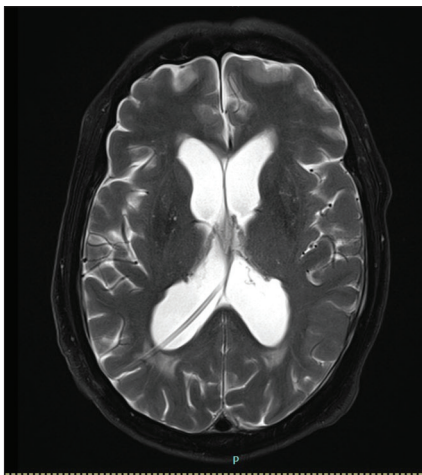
MRI brain: Pan ventriculomegaly with patent shunt *in situ*.
